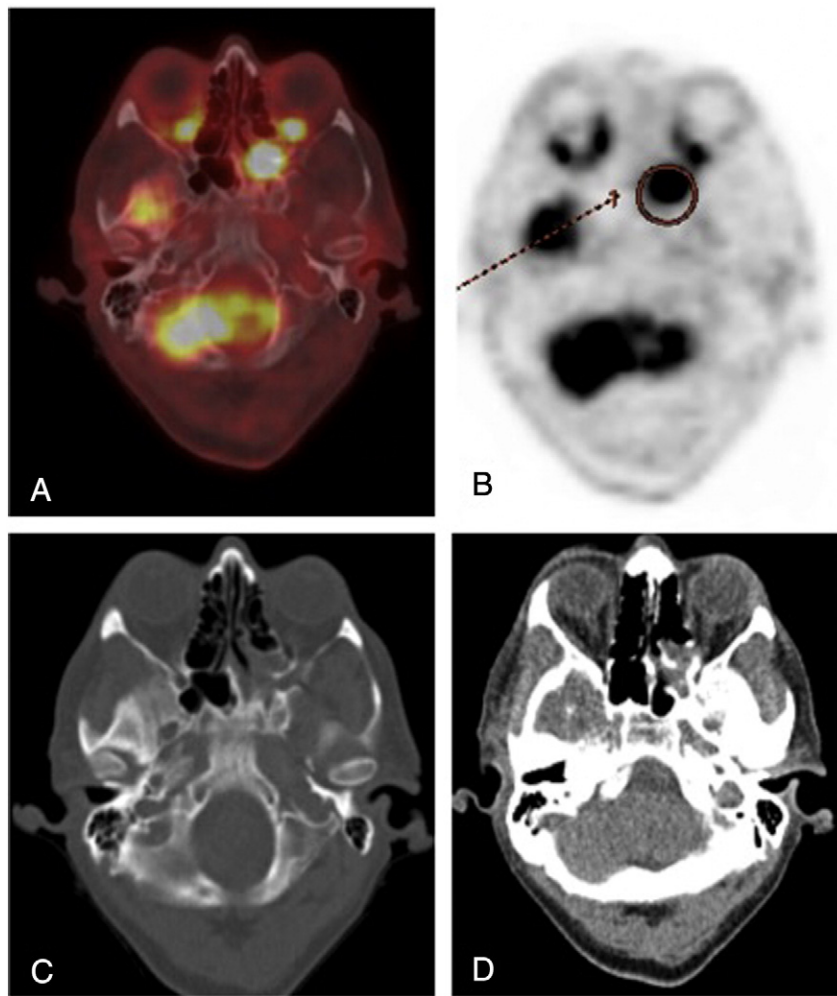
PET-CT findings in cryptococcal sinusitis. Axial images through the level of the orbits are shown. (A) Axial Fused PET and CT image; (B) Axial PET Image; (C) Axial CT Image; bone window; (D) Axial CT Image, soft tissue window. A hypermetabolic soft tissue mass is identified in the left sphenoid sinus (arrow in image (B)). There is no evidence of associated osseous destruction.
